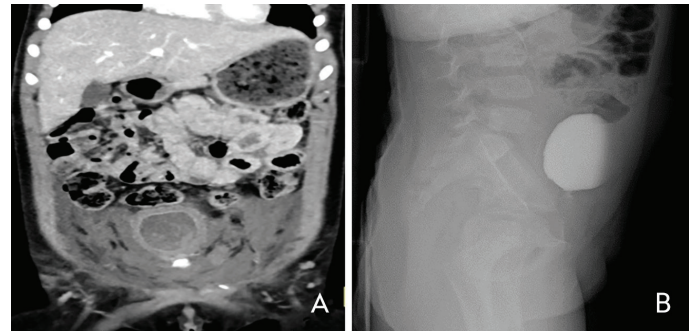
A) Computed abdominal tomography showing a hematoma around bladder neck, associated with fracture of superior pubic ramus and extravasation of contrast material. B) Subsequently performed lateral abdominal radiography demonstrating a high-situated bladder filled with contrast material
